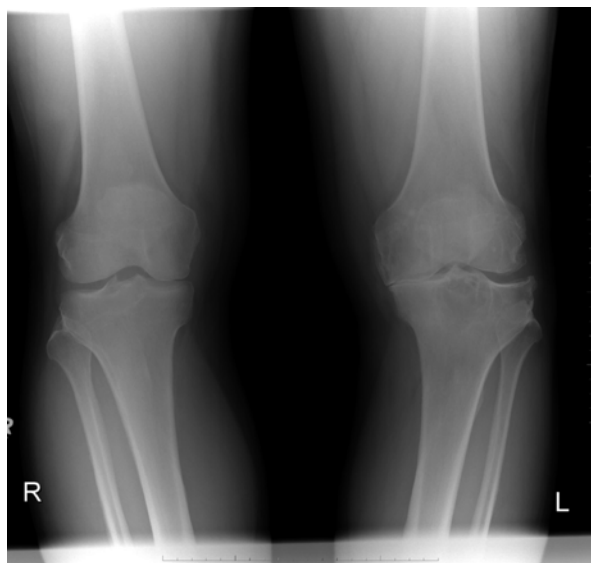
Frontal radiograph of the knees demonstrating bilateral knee OA. There are features of severe OA in the left knee with bone on bone joint space loss in the medial compartment, large osteophytes, subchondral sclerosis, and a large cyst in the subspineous tibial plateau. Mild findings indicating early OA are seen in the right knee with spurring of the tibial spines and mild medial joint space narrowing. There is also varus malalignment of the knees, worse on the *left*
